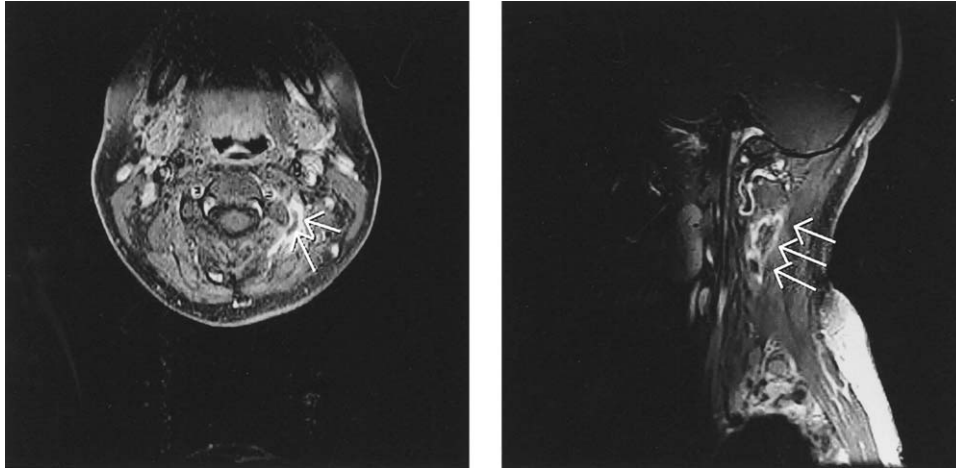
Axial T1 (left) and sagittal T1 (right) post-contrast MRI images showing ring-enhancing fluid collection in the left paraspinal muscles on the day of admission, 7 days after her C2–4 radiofrequency lesioning.
